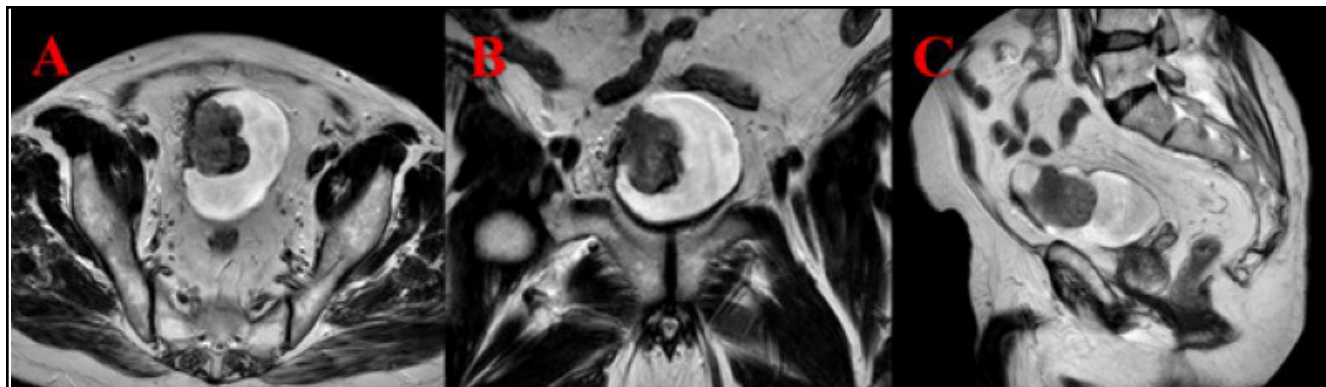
Contrast-enhanced MRI images of the bladder mass prior to TUR resection; axial (A), coronal (B), and sagittal (C) sections.
